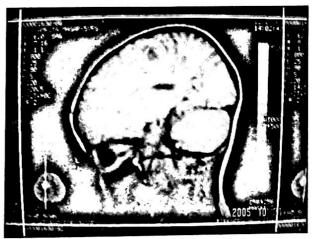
Preoperative MRI scan head
